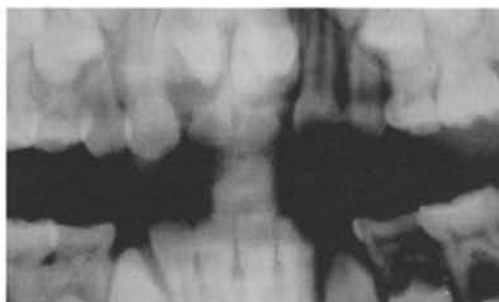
A - Radiograph showing supernumerary teeth in the maxillary midline (mesiodens). Note delayed eruption of the permanent central incisors.
